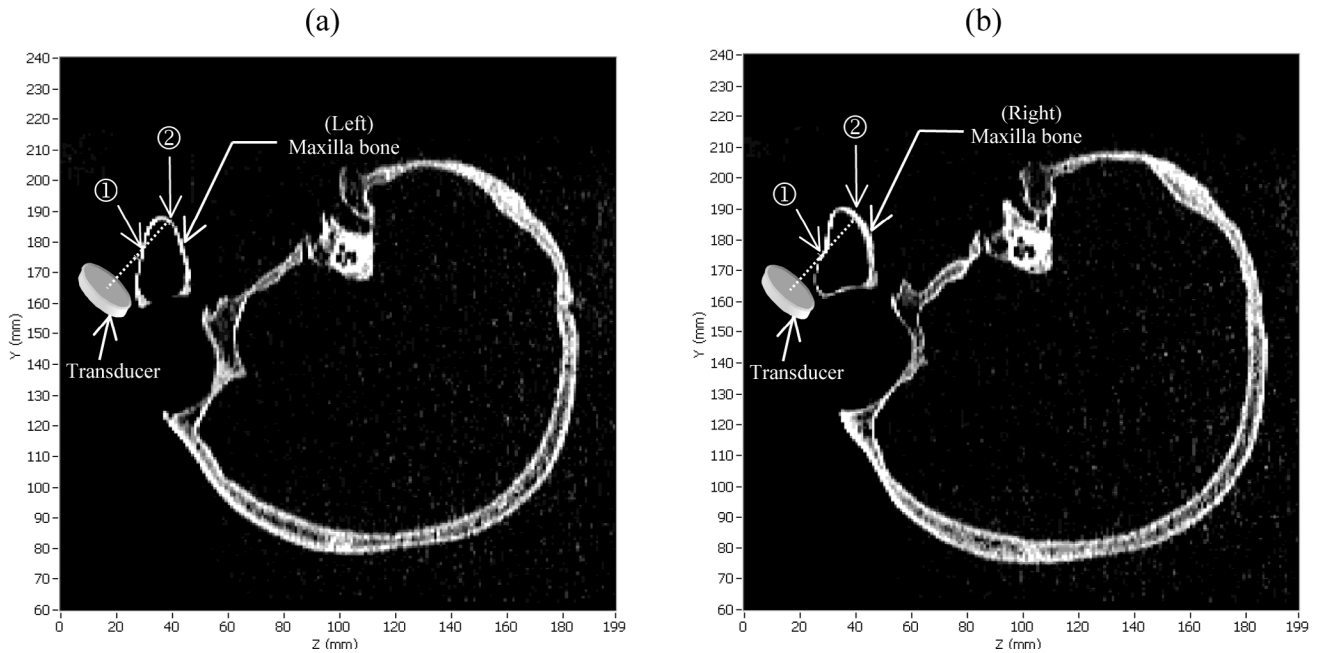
Sagittal CT images of the skull (upside down), with indication of the transducer position for shear propagation, showing the (a) left and (b) right maxillary sinuses of the *ex vivo* human skull used in the sinus fluid detection experiment.
